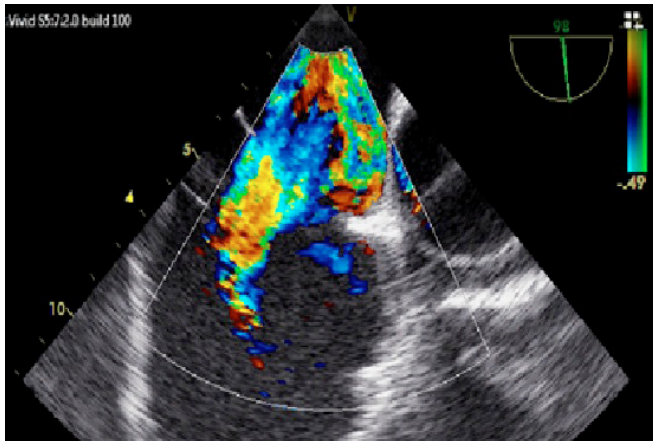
Transesophageal echocardiographic images showing a narrow color flow jet passing through the right atrium to the left atrium.
